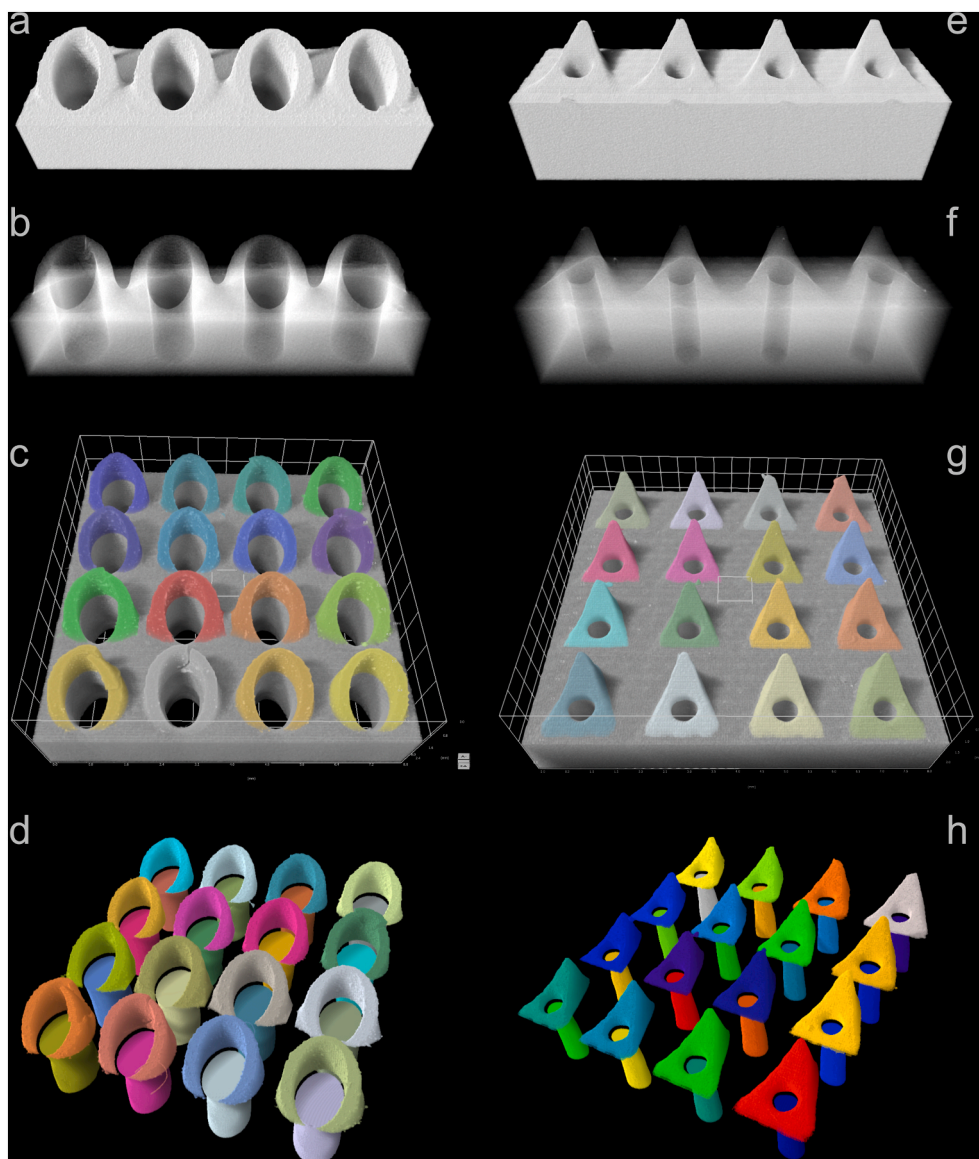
X-ray μ CT of curved pyramid, syringe-like HMNs and their microchannels. Volumetric (a), (e) and semitransparent (b), (f) virtual section of a single needle row showing the needle structure and the lumen with respect to the needle. Sub-panels (c), (d) and (g), (h) show the segmented individual needles (c), (g) and the needle/lumen models (d), (h) used for the volumetric quantification of the structures presented in Table 2. Grid-size 0.8 mm and 0.5 mm in (c) and (g) respectively.
